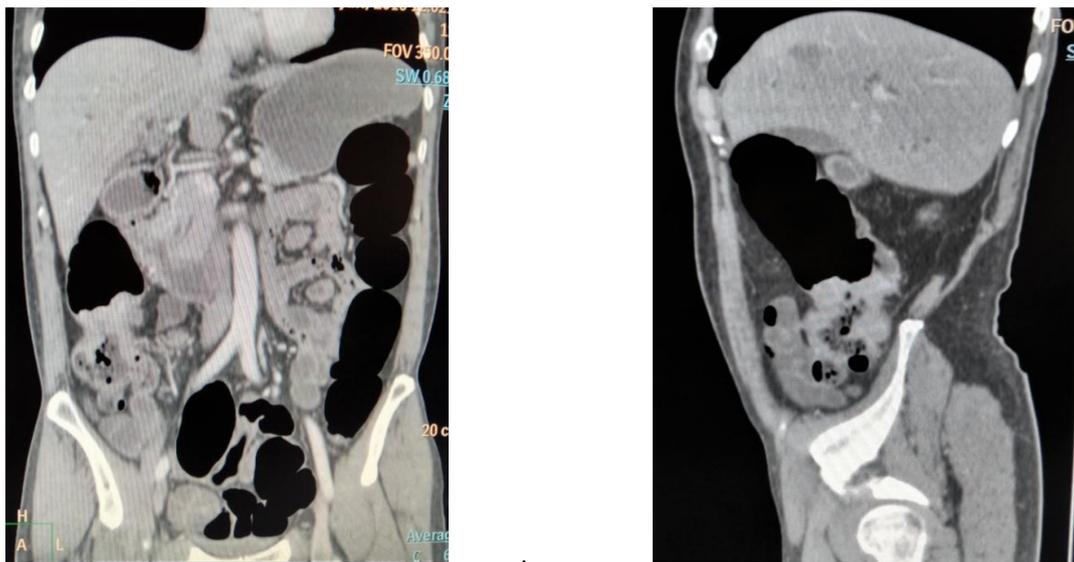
(a) Axial CT view of the ascending colon mass causing luminal obstruction, (b)CT Colonographic view of the luminal polypoidal mass causing luminal obstruction.
